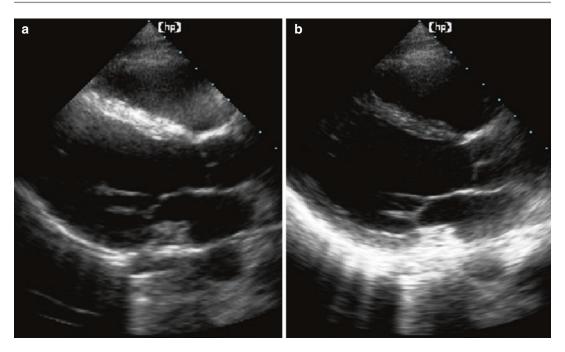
Parasternal long-axis images showing the improper application of the TGC control. Image "a" shows excessive gain in the septum while "b" has too much gain in the posterior pericardial area
